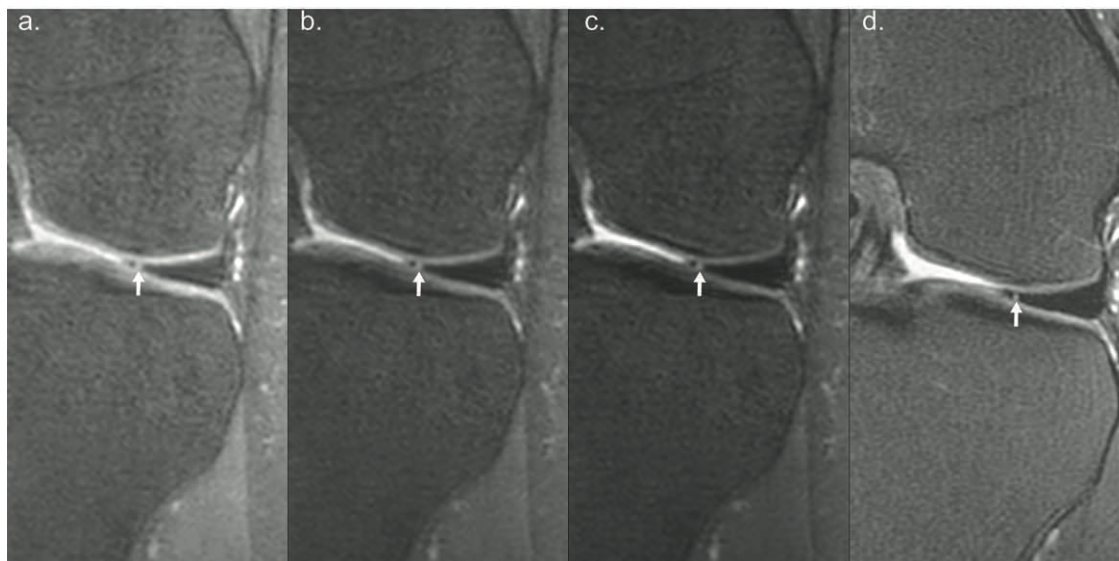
A 16-year-old girl with lateral meniscus tear. Subtle tear of the lateral meniscus (arrows) is seen equally on (a-c) T2 Shuffling PD, intermediate, and T2W coronal reformatted images and (d) conventional 2D FSE FS T2W coronal knee MRI.
